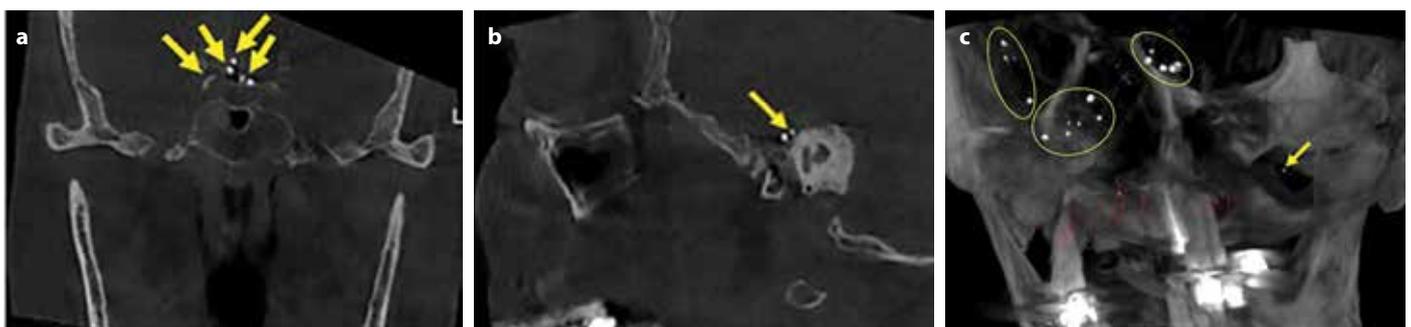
a-c. Multiple small rounded radiopacities (yellow circles and arrows) can be seen in the intracranial region of case 2 (a) coronal CBCT section of sella turcica region, (b) sagittal CBCT section of left temporal bone, (c) 3-dimensional reconstruction image.
